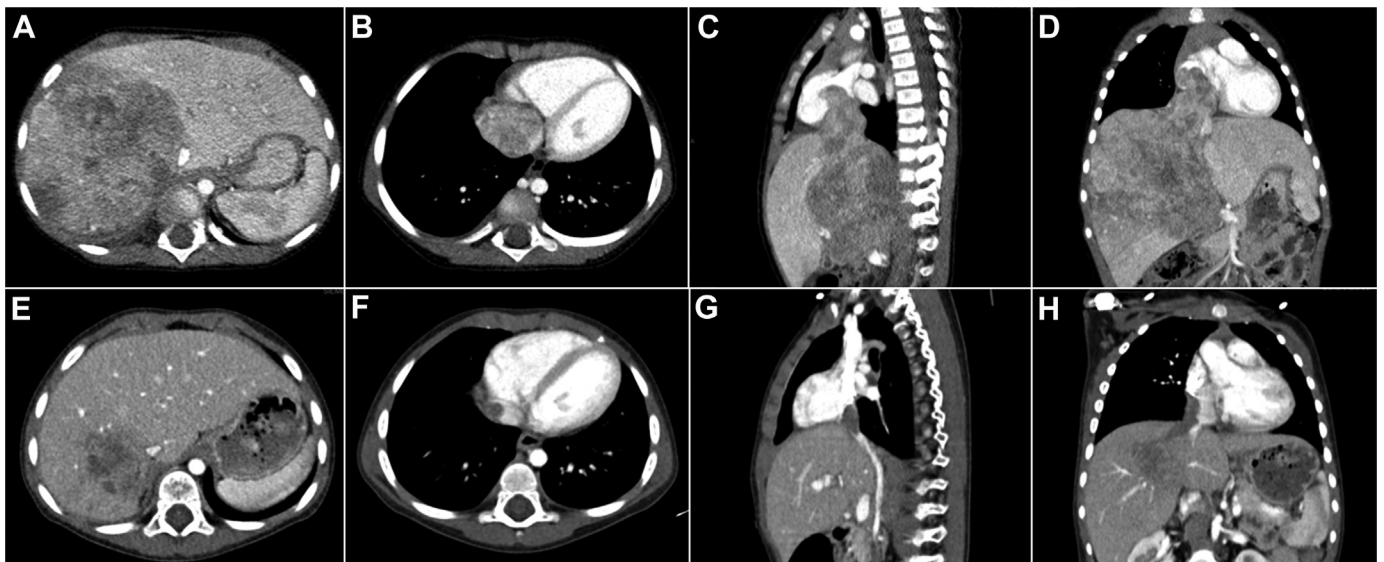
Radiological presentation on injected CT of the tumor at diagnosis (A–D) and after 2 courses of chemotherapy (SIOPEL IV HR) at the time of surgery (E–H). Size at diagnosis was $94 \times 90 \times 128$ mm for the main liver tumor and 36×28 mm for the tumor in the right atrium; pre-operatively the main tumor was reduced to $48 \times 40 \times 49$ mm and the tumoral extension to the IVC and the right atrium to $11 \times 11 \times 27$ mm.
